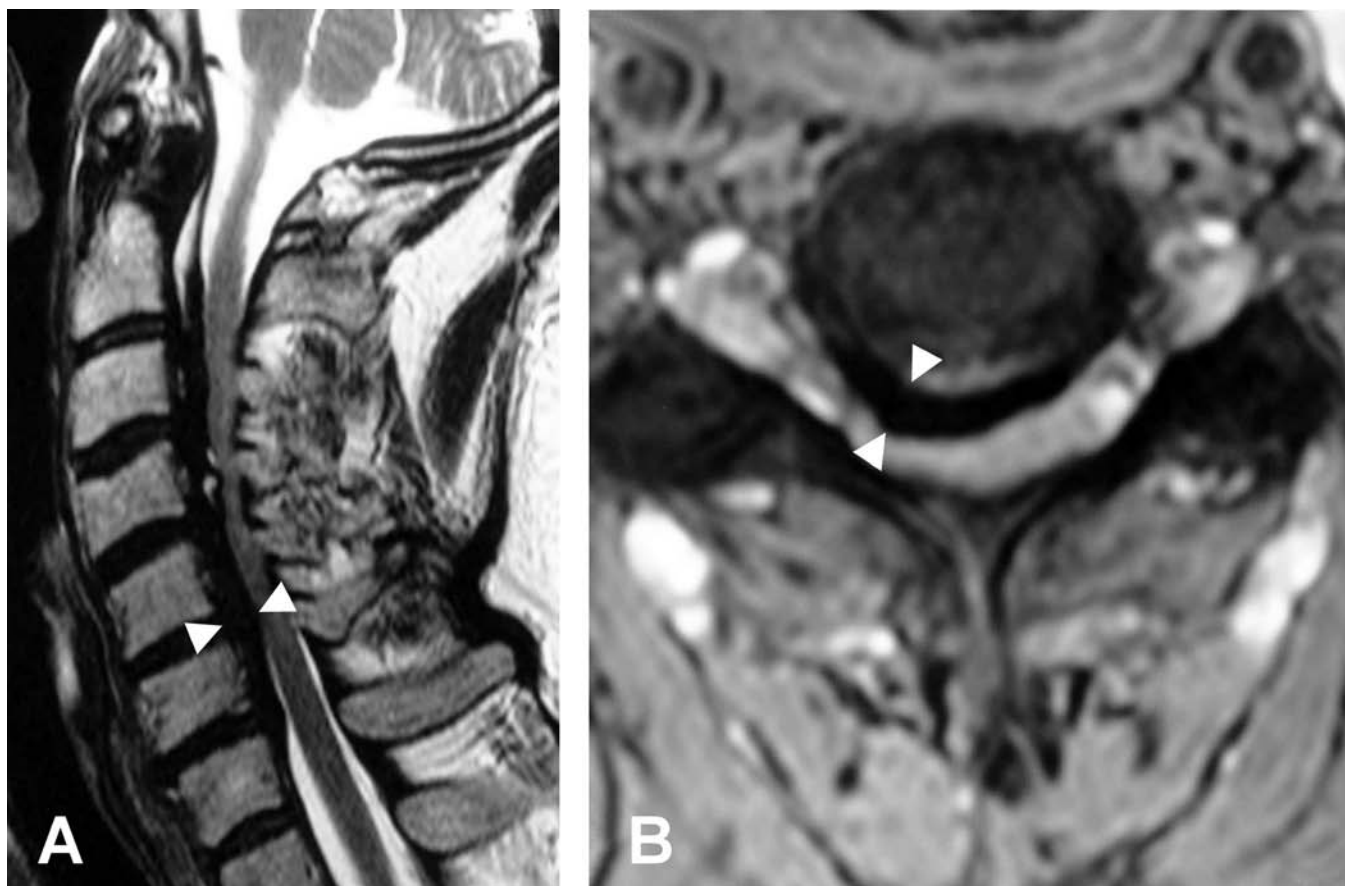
Sagittal (A) and axial (B) T2-weighted MRI reveals marked ossification of the posterior longitudinal ligament (arrowheads), resulting in severe cervical spinal canal stenosis with compression of the spinal cord.
